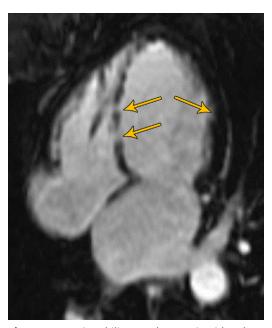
Eosinophilic granulomatosis with polyangiitis in a 56-year-old woman. Four-chamber late gadolinum-enhanced MR image shows multiple subendocardial and transmural infarctions (arrows).
